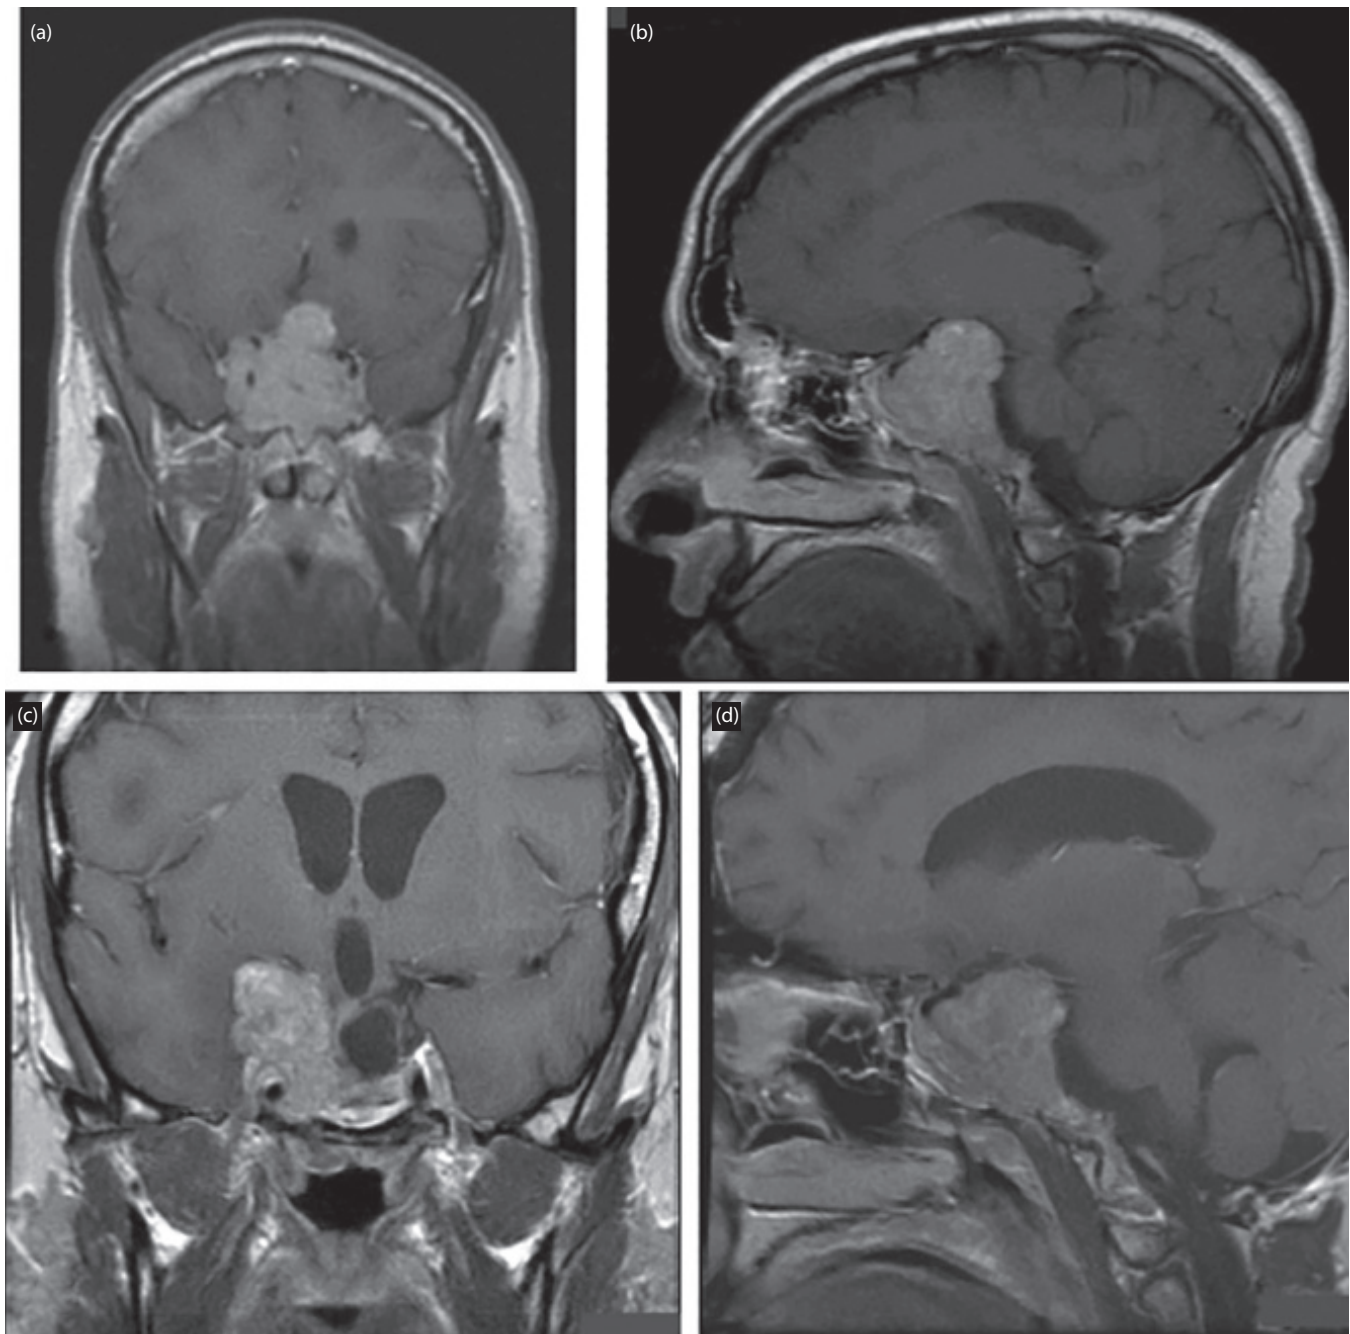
Coronal (a) and sagittal (b) post contrast MRI showing a large sellar–suprasellar prolactinoma pre medical therapy and coronal (c) and sagittal (d) post contrast MRI 3 months after initiating medical therapy with significant decrease in left side of the tumor.
